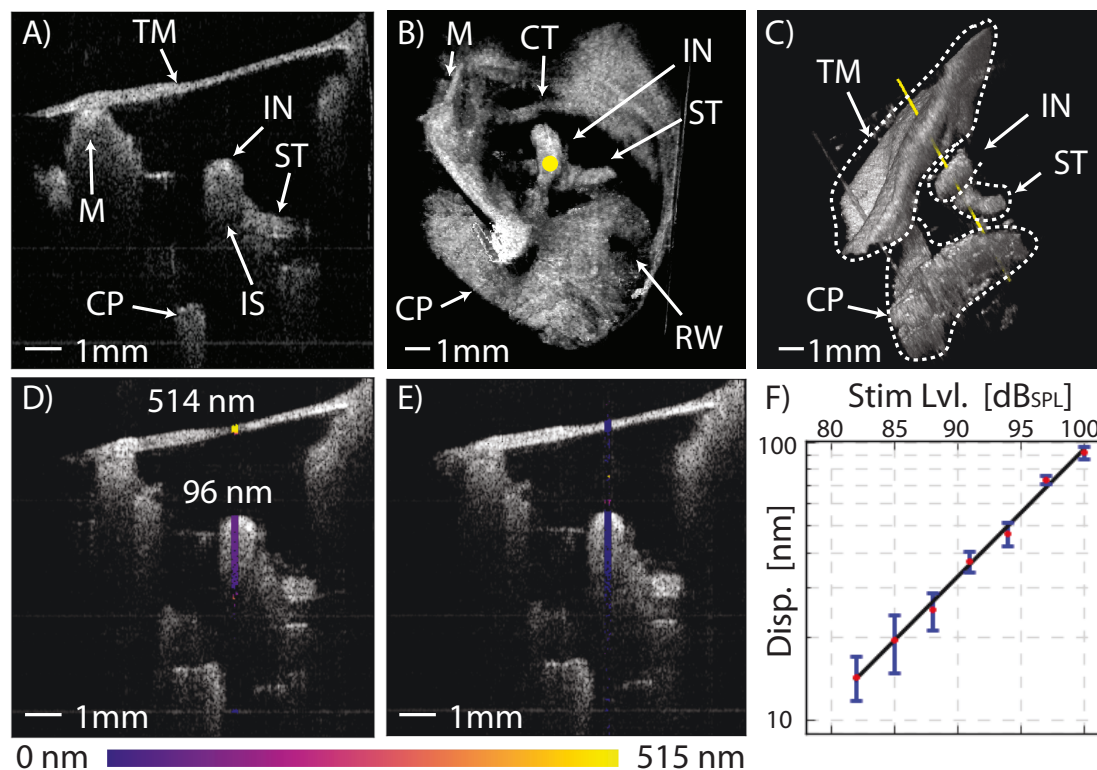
In vivo* real-time OCT-DV measurement in a normal left ear's response to sound at 1030Hz. A shows a $10 \times 10\text{mm}^2$ 2D cross-section of the middle ear in the transverse plane. Supplementary File C shows the macroscopic changes to the ear anatomy during a Valsalva maneuver. B Shows a $10 \times 10 \times 10\text{mm}^3$ 3D volume render of the middle ear as seen from the perspective of the ear canal with the TM digitally removed (see Supplementary File D). C, shows the same volume from an inferior-posterior perspective with the TM in-place showing the axis of OCT-DV measurement along the yellow line passing through the incus at the stapedius tendon. Functional measurements of the TM and incus' peak-to-peak vibrational response at 1030Hz are shown in D with a $P_0 = 100\text{dB}_{SPL}$ tone applied to the ear and in E without stimulus. F, Peak-to-peak displacement of the incus versus presentation level showing good linearity from 80dB_{SPL} to 100dB_{SPL} . Error bars represent \pm one standard deviation of the response over the pixels along the axial length of the incus. TM tympanic membrane, M malleus, IN incus, IS incudostapedial joint, ST stapedius tendon, CT chorda tympani, CP cochlear promontory, RW round window.
